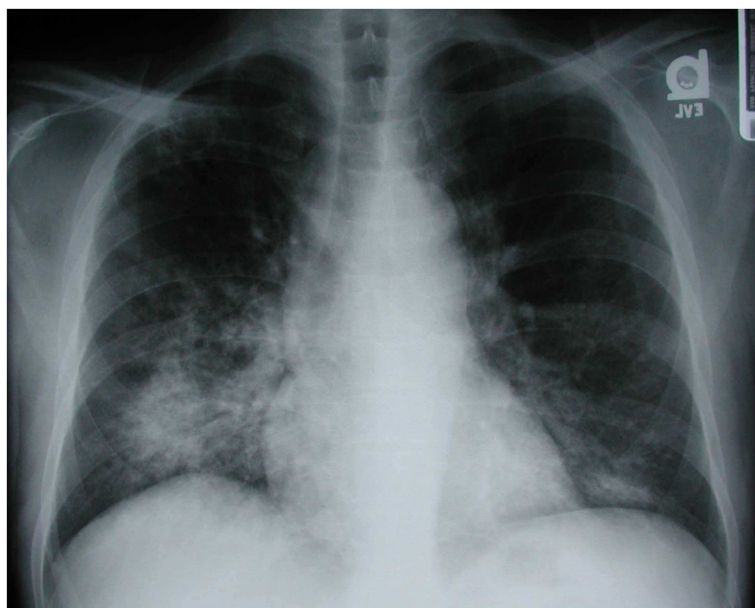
Chest radiograph of an HIV-infected patient with isolated cryptococcal pneumonia. There is a focal consolidation in the right lower lobe with areas of cavitation. Courtesy of Laurence Huang, MD; used with permission.
